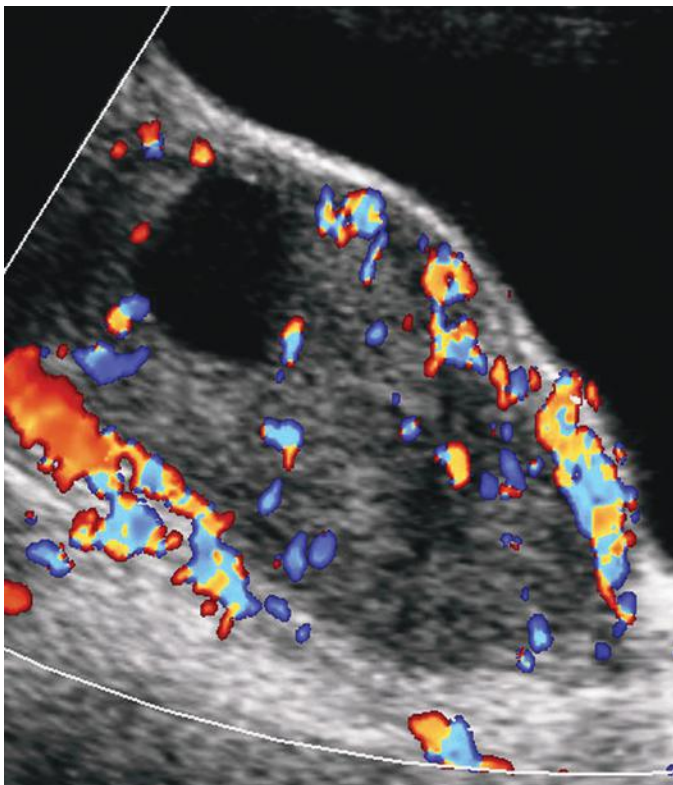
Granulosa cell tumor in a 16-year-old girl undergoing evaluation for primary amenorrhea. Sagittal color Doppler ultrasound image shows a predominantly solid pelvic mass with a prominent anechoic cystic component.
